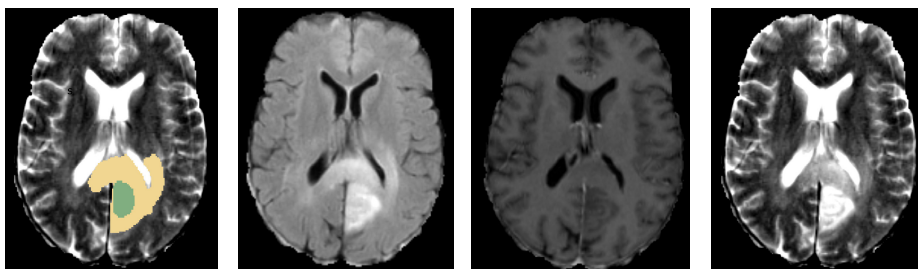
Qualitative validation set result. Selection criteria for cases were based on best, worst, median, and 75th and 25th percentile. From left to right: FLAIR image with overlay of generated segmentation, FLAIR image, T1ce image, and T2 image. Edema is shown in yellow, necrosis in green and enhancing tumor in blue.
